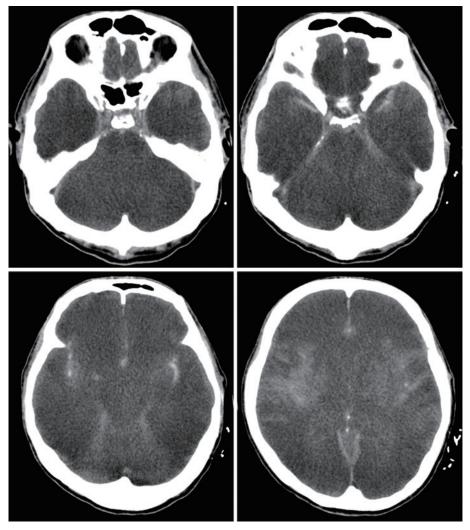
Noncontrast brain computed tomography reveals diffuse brain edema, loss of gray-white matter contrast, and abnormally highly dense subarachnoid spaces of the basal and Sylvian cisterns and sulci.
